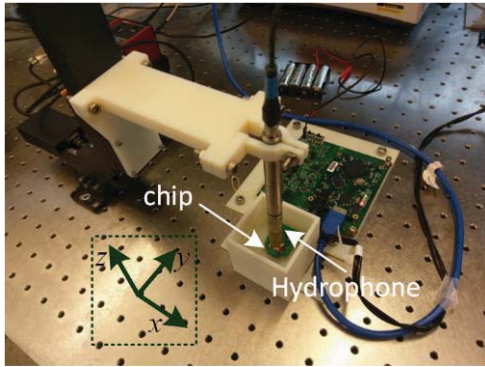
Ultrasound measurement setup.
